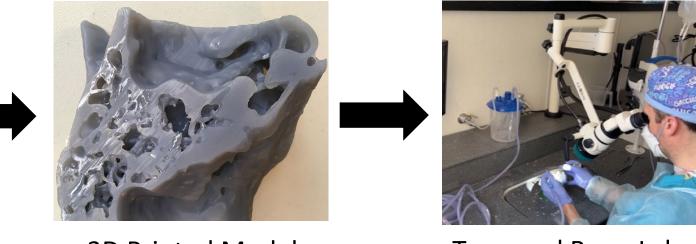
Three CT scans were used to make both virtual
